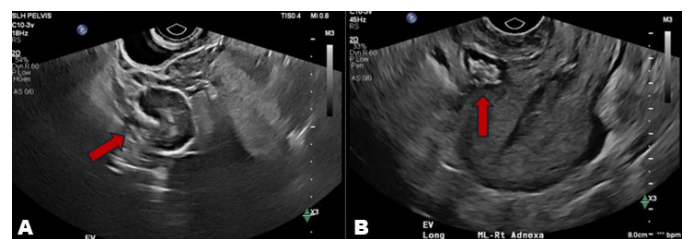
Transvaginal ultrasound showing a complex cystic structure in the right adnexa measuring about $5.6 \times 5.0 \times 5.5$ cm with hazy posterior acoustic shadowing. No retained products of conception noted within the endometrial canal, only fluid. (A) Transverse view of right adnexa. (B) Longitudinal view of right adnexa with endometrium showing no intrauterine products.
